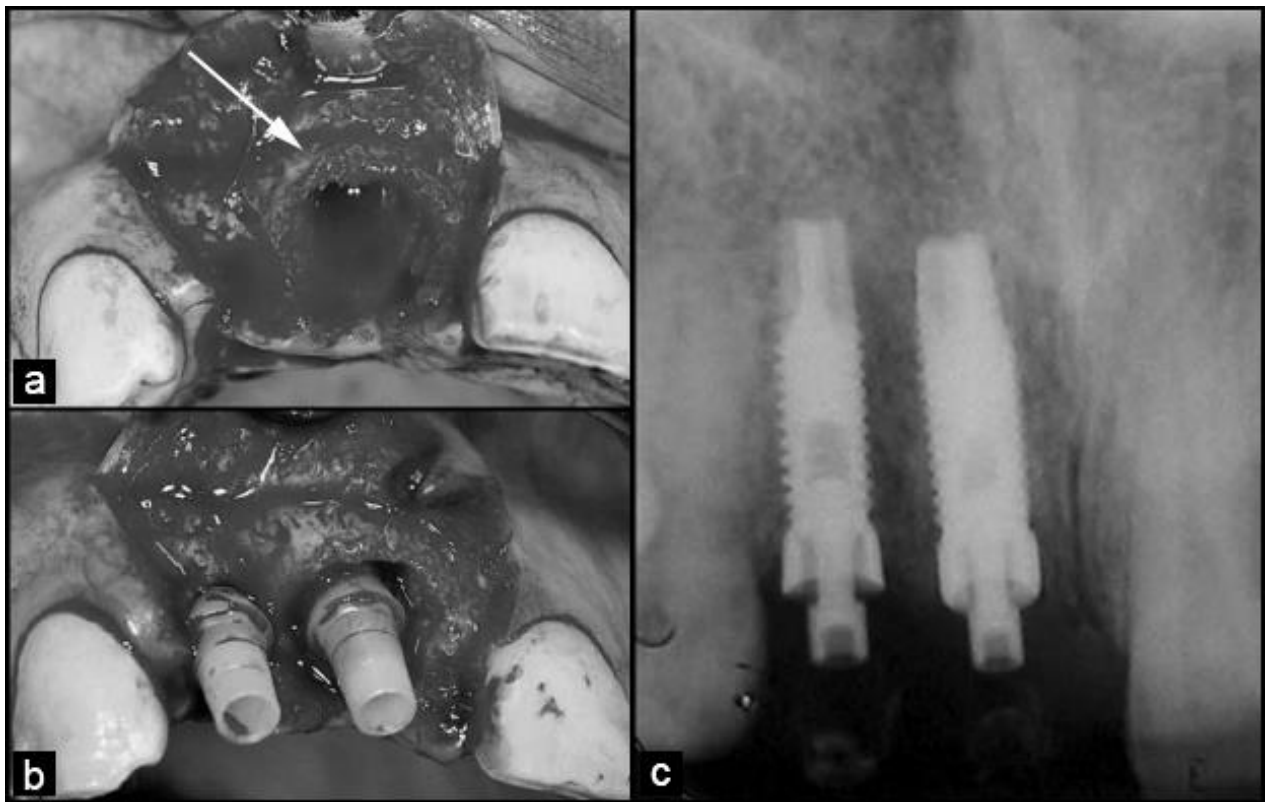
a) Atraumatic extraction of tooth No. 11. Note the preservation of the thin labial plate of the socket (arrow); b) Connection of 2 prefabricated temporary plastic abutments; c) Periapical radiograph taken immediately after implant placement and connection of 2 temporary abutments for immediate loading.
